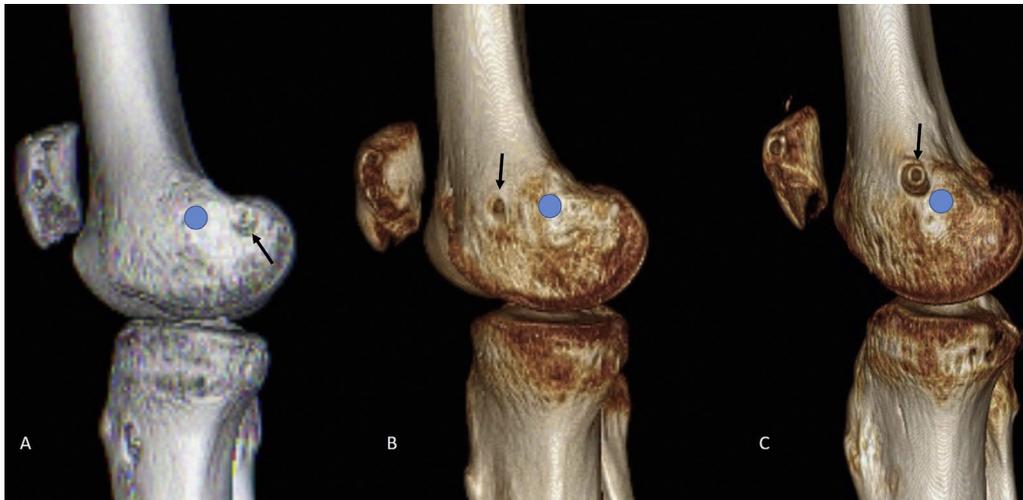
(A,B and C): 3-D reconstruction of CT scan showing three images with mal-positioned tunnel (black arrow) in posterior (4A), anterior (4B) and superior (4C) direction. Blue circle indicates position of Schottle point.
